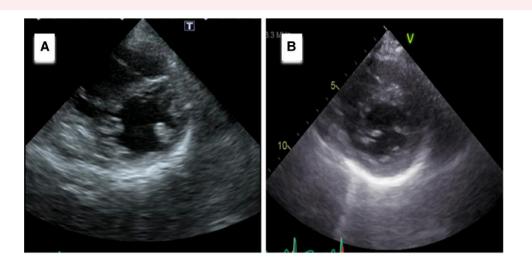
Changes in echocardiographic findings of short-axis view. Serial changes in the short-axis view on Day 10 (A) and after a month following discharge (B).
